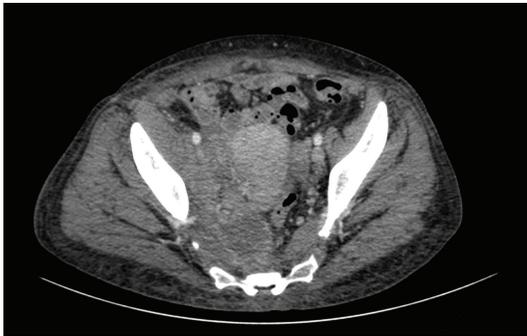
Computed tomography (CT) scan showed the mass occupying the retroperitoneal space infiltrating the psoas muscle posteriorly and the pelvis anteriorly.
